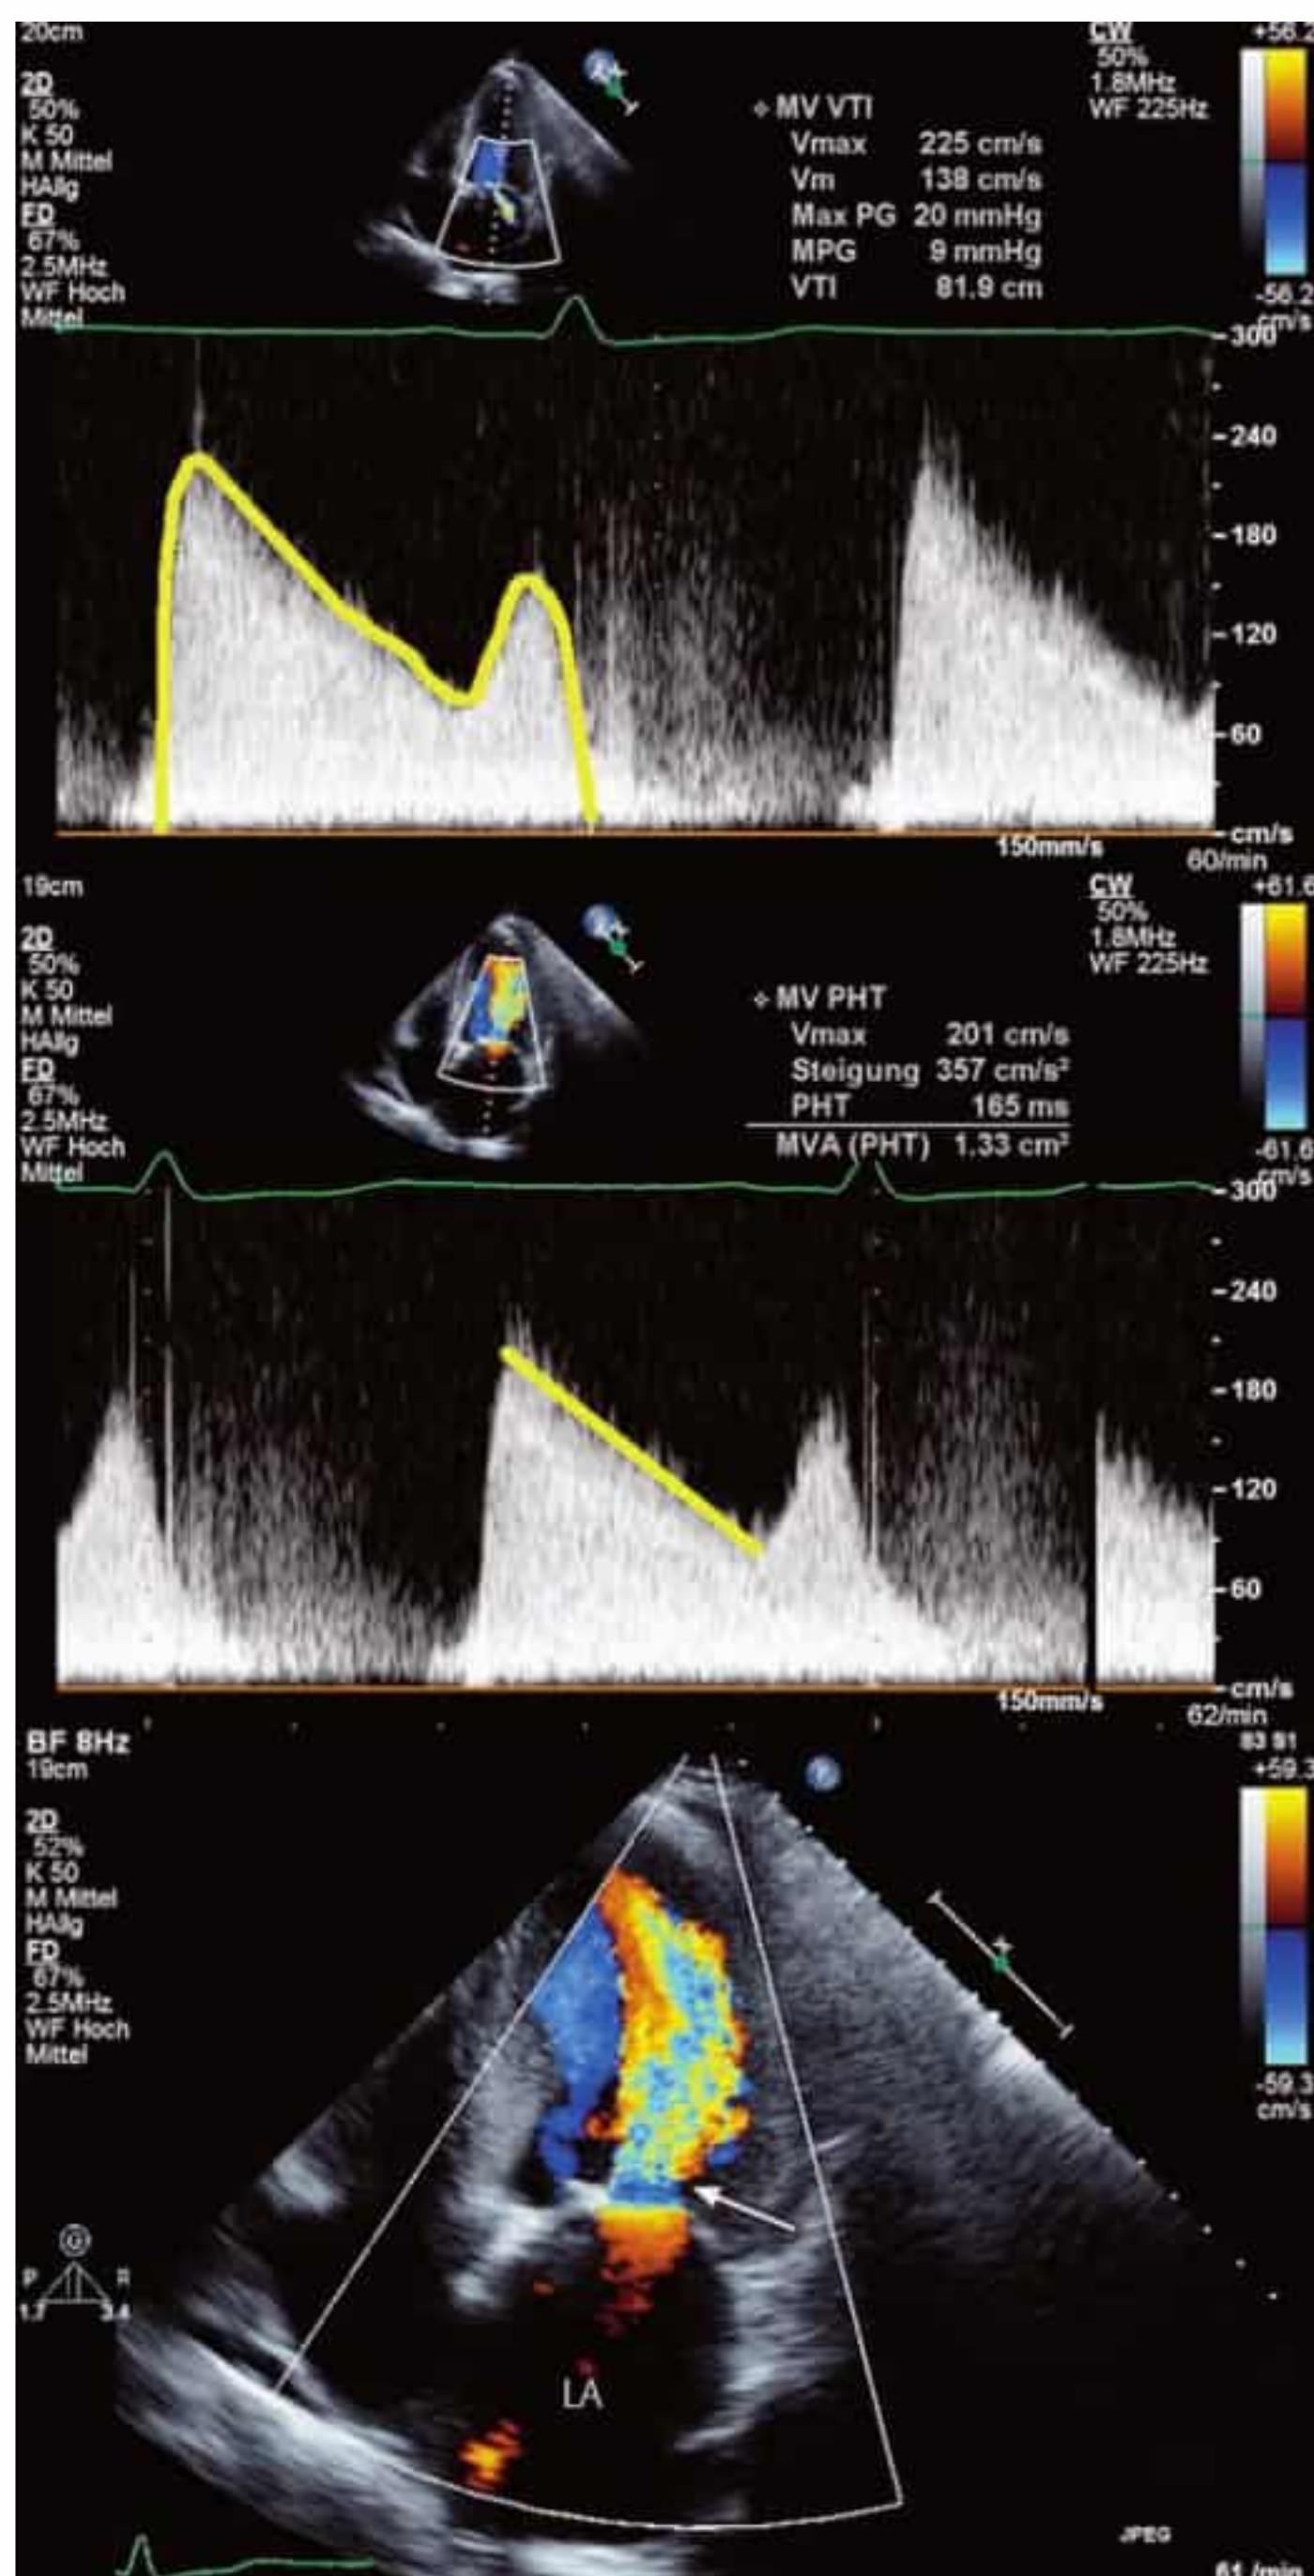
Evaluation of mitral stenosis by Doppler echocardiography, with measurement of the mean pressure gradient (MPG = 9 mmHg, top) and estimation of the valve orifice area (MVA = 1.33 cm²) based on the PHT (165 ms, center). Imaging in color Doppler mode shows a typical narrow inflow jet with aliasing proximal to the stenosis (bottom, arrow).
